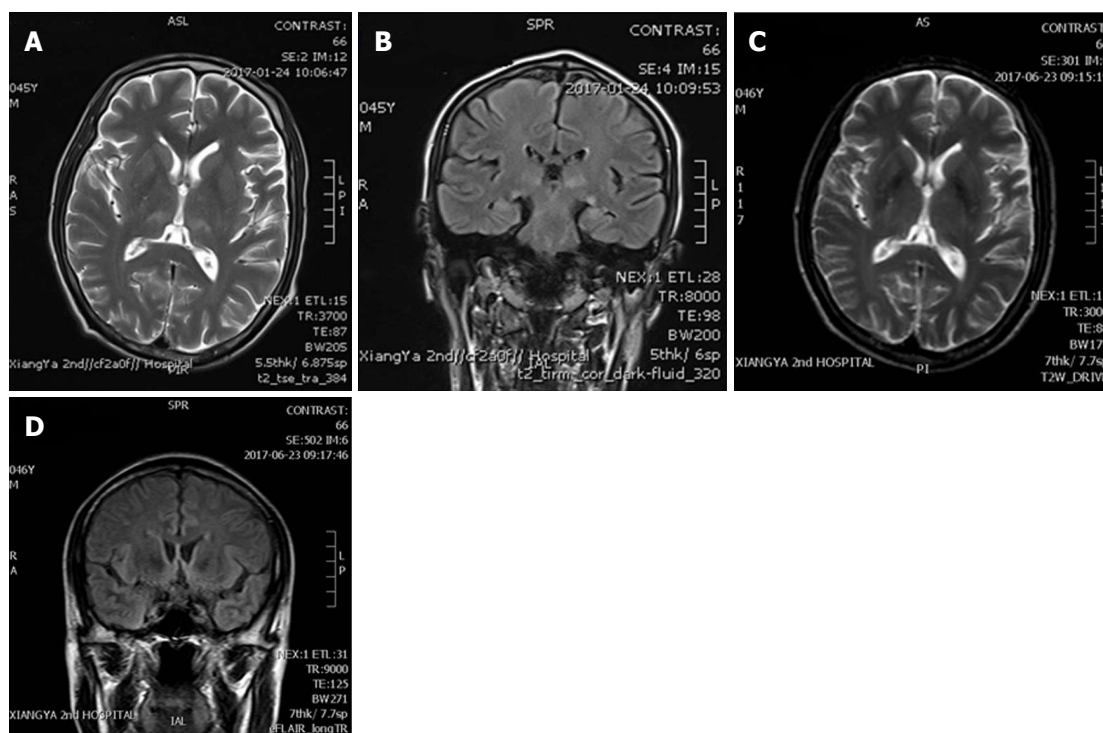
Brain magnetic resonance imaging. (A) and (B) are MRIs taken before the thiamine treatment, while (C) and (D) are from 5 mo after the thiamine treatment. A: Symmetrical high T2 signal intensities in pons; B: Symmetrical high T2 signal intensities in paraventricular area; C: Reduction of abnormal signal in pons; D: Reduction of abnormal signal in paraventricular area. MRI: Magnetic resonance imaging.
